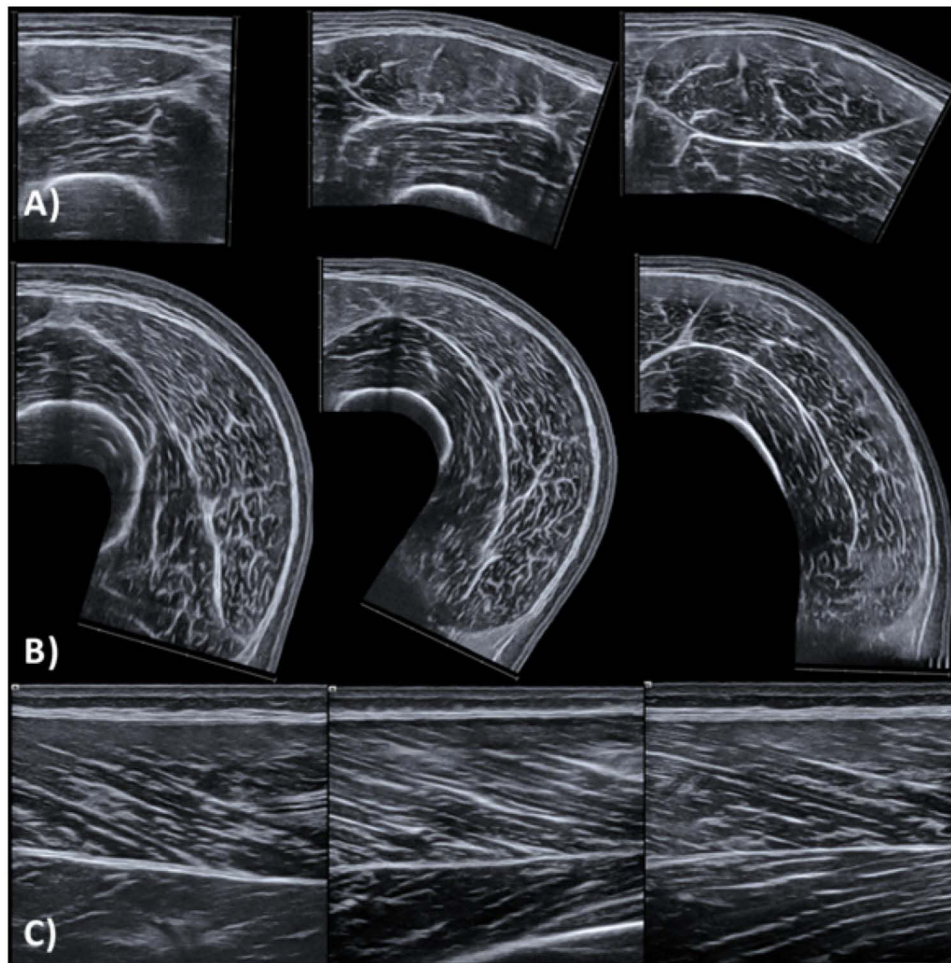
Ultrasonography images of one player at all scanned locations and planes. (A) rectus femoris anatomical cross-sectional area at 66%, 50% and 33% of femur length (from left to right). (B) vastus lateralis cross-sectional area at 66%, 50% and 33% of femur length. (C) vastus lateralis architecture at 66%, 50% and 33% of femur length.
